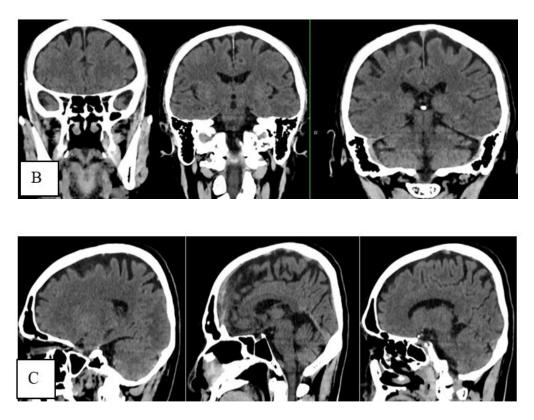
Head CT scan without contrast, showing normal slices in A. Axial; B. Coronal; and C. Sagittal views.
